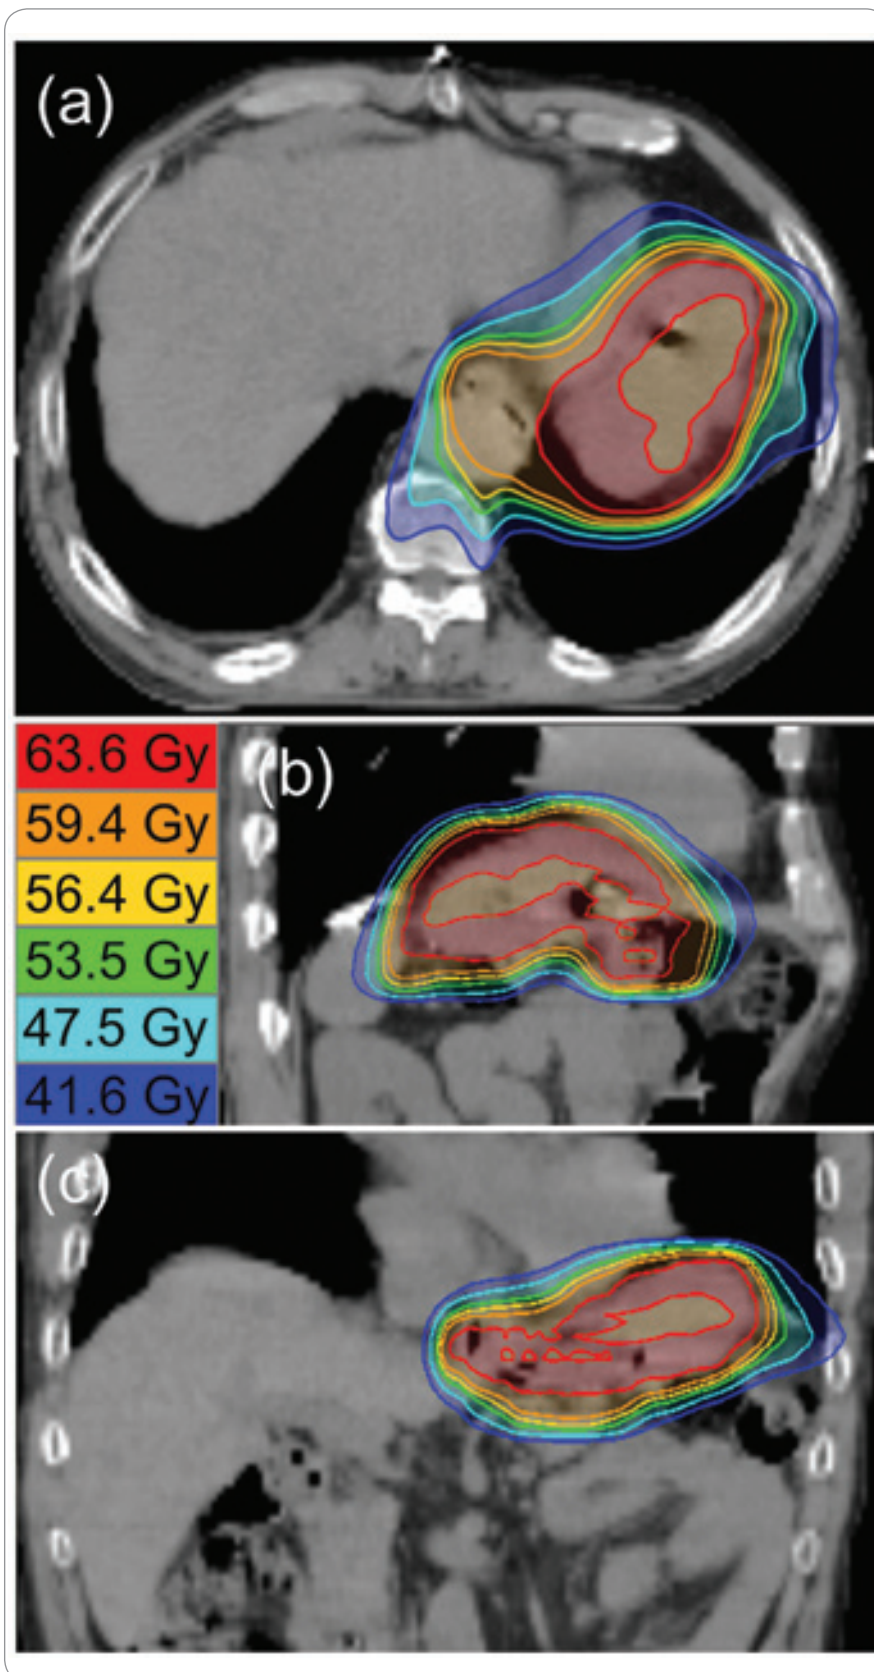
Radiotherapy isodose line distribution. Isodose lines are displayed on (a) transverse, (b) coronal and (c) sagittal CT imaging. Isodose lines with corresponding actual radiation dose were given over 33 fractions.
